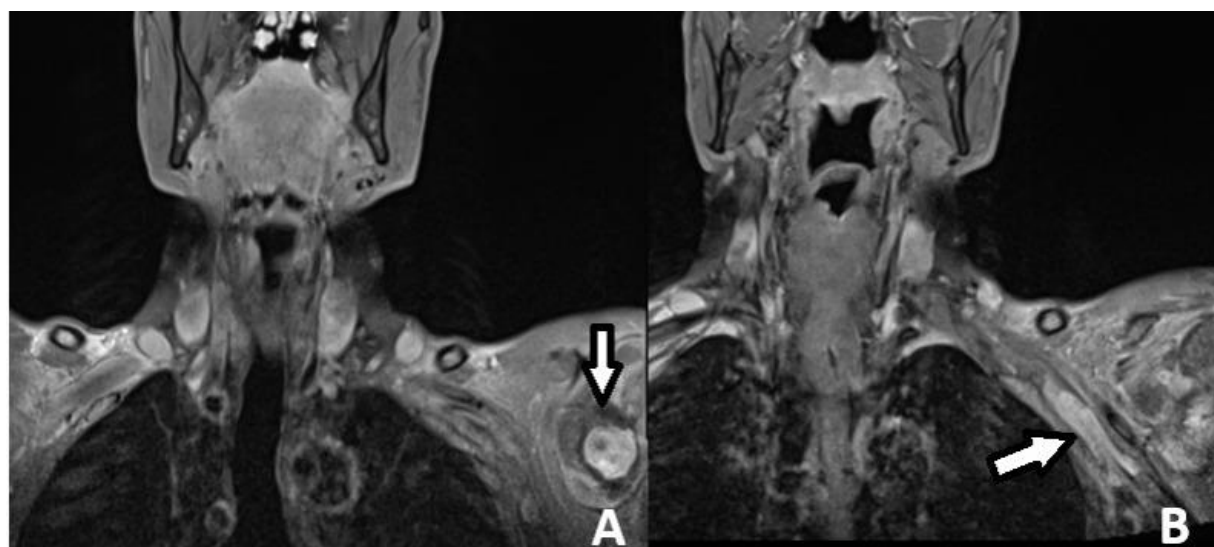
Coronal magnetic resonance images showing a pseudoaneurysm in the supraclavicular region producing compressive mass effect on the adjacent brachial plexus (arrows).
